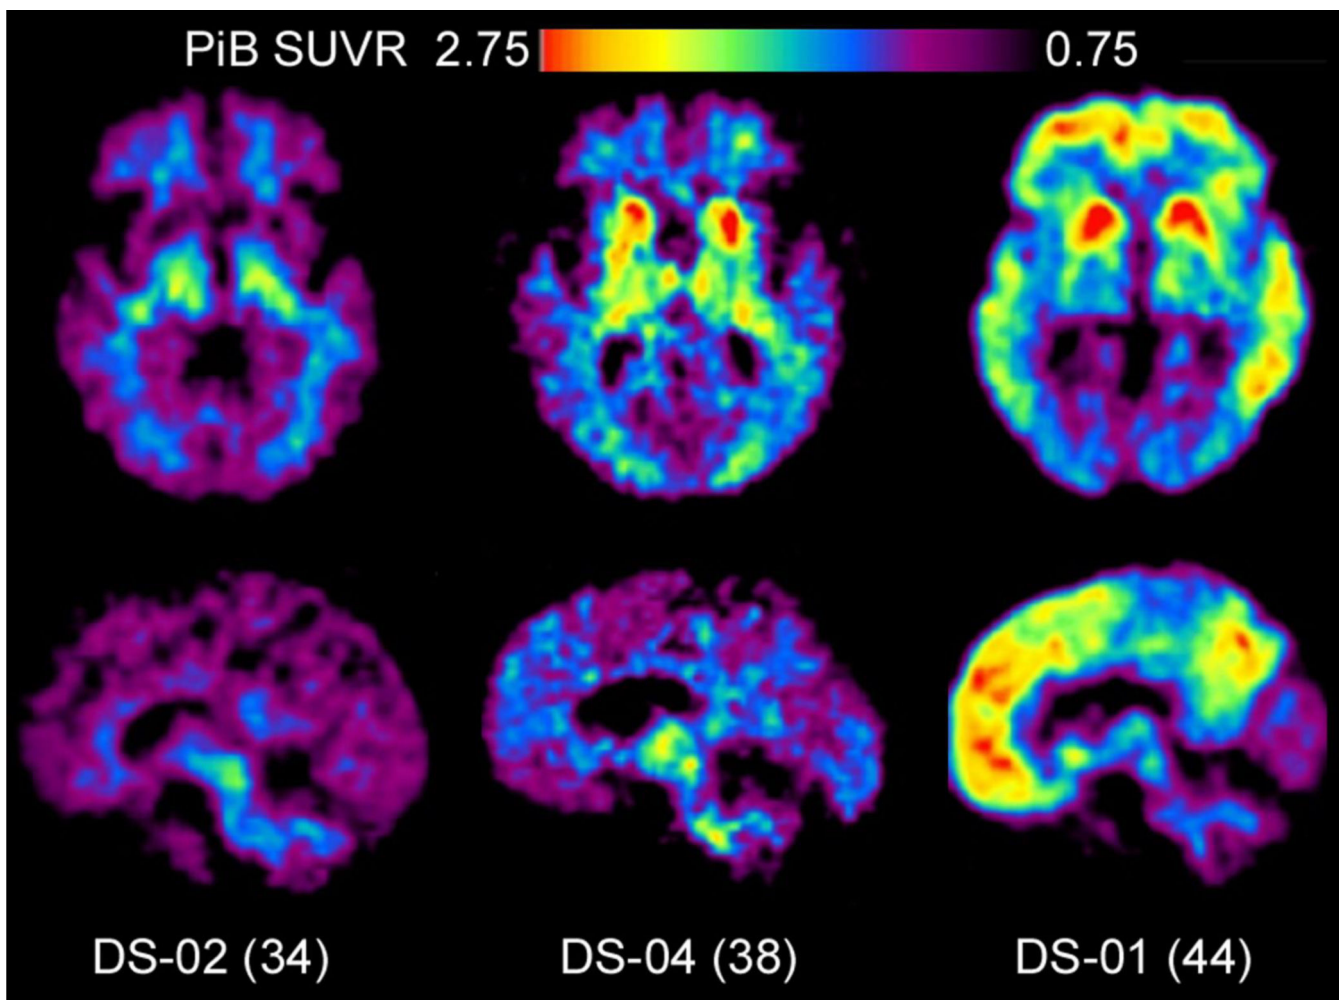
Pittsburgh compound B (PiB) standardized uptake value ratio (SUVR) images of subjects with DS showing different levels of ligand retention (the axial images are shown at the top and the sagittal images at the bottom). Left: Amyloid-negative 34 year-old DS subject showing only nonspecific PiB retention in white matter; Middle: Moderately amyloid-positive 38 year-old DS subject showing early striatal PiB retention; and Right: Heavily amyloid-positive 44 year-old DS subject which is very similar to those seen in late-onset AD, but with a predominant striatal signal. Adapted from Handen et al., 2012.
